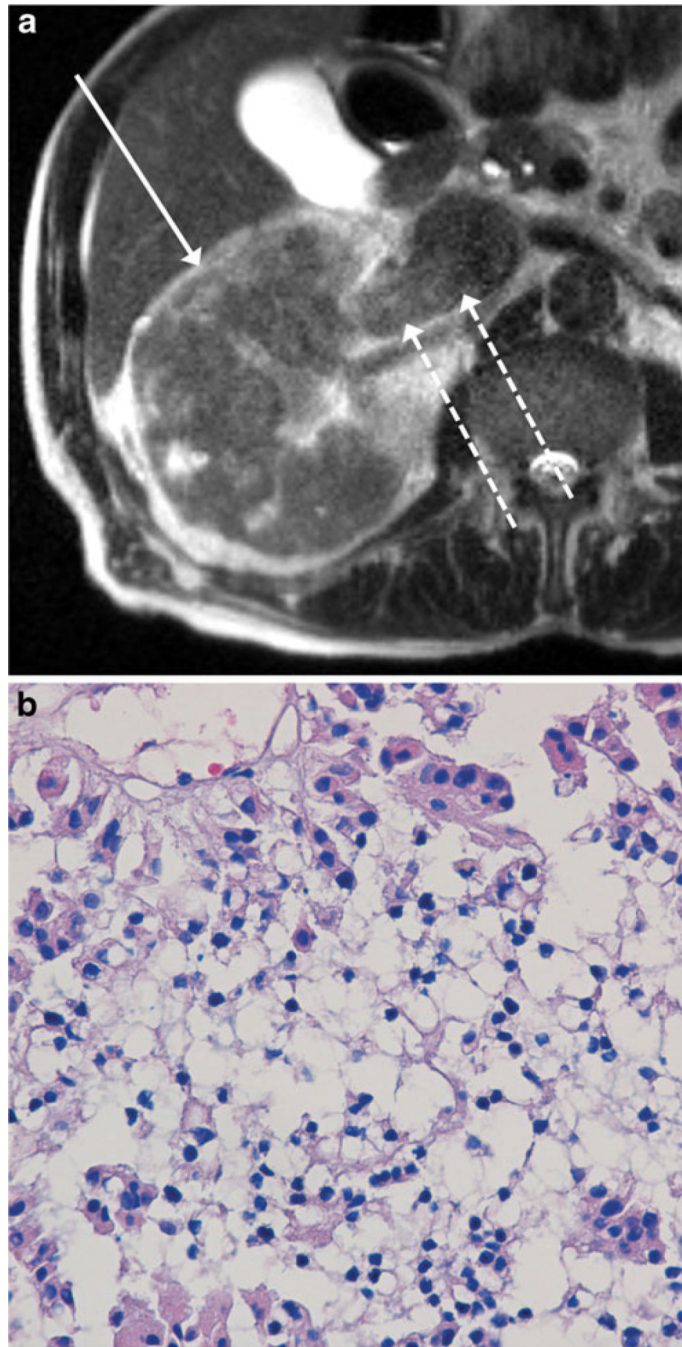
MR images of a 79-year-old man with a renal mass. Axial single-shot T2-weighted image (a) shows a large T2-hypointense poorly encapsulated infiltrative mass involving nearly the entire right renal parenchyma (*solid arrow*), consistent with MRI appearance III. There is also tumour thrombus throughout the right renal vein and extending into the inferior vena cava (IVC) (*dashed arrows*). Although the mass was diagnosed as a type 2 papillary renal cell carcinoma (pRCC) at total nephrectomy, the mass was classified as infiltrative pRCC in our study. Section of tumour (b) shows a central area with small neoplastic nuclei without
